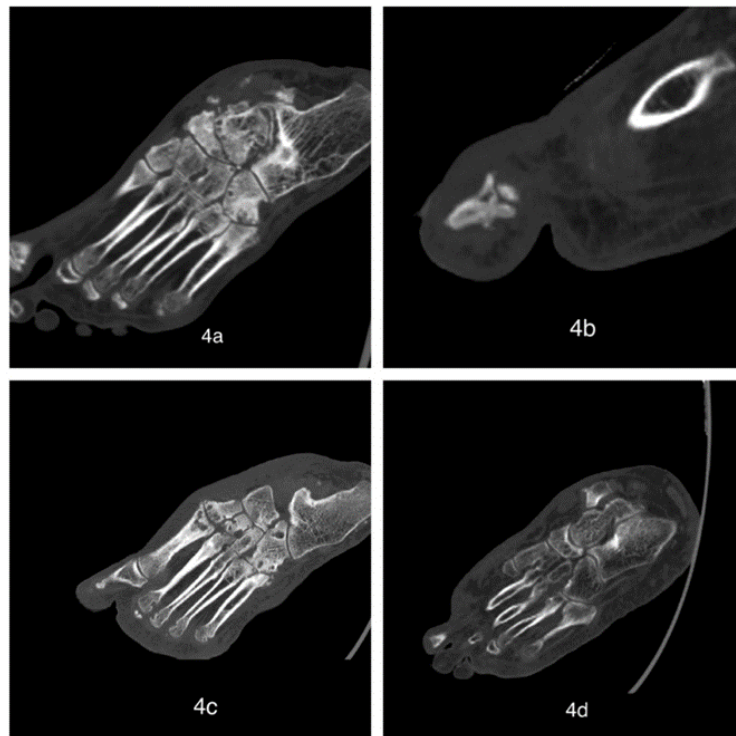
Shows various CT changes seen in diabetic foot referred to in the article.
